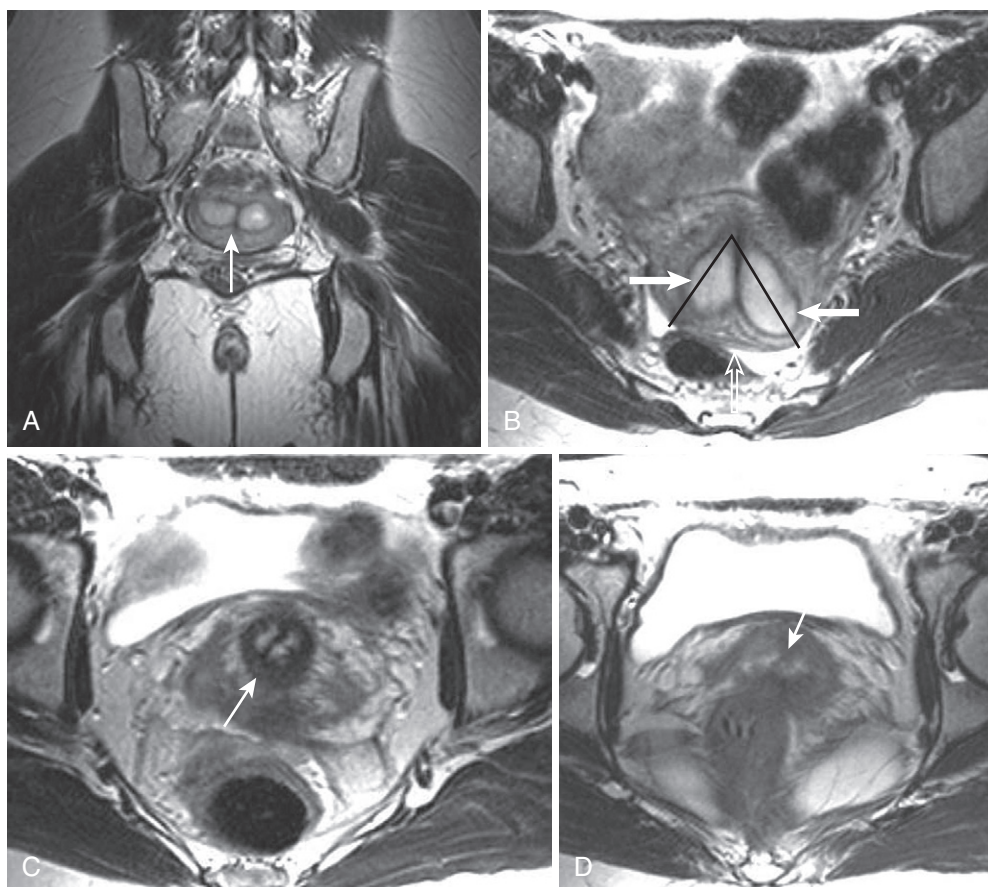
Septate uterus. A, Coronal T2-weighted image shows a hypointense fibrous septum (*arrow*) dividing the endometrial hemicavities. Axial T2-weighted images show the fibrous septum extending from the uterine fundus (B) through the cervix (C) and into the upper vagina (D) and confirming features consistent with septate uterus—convex outer fundal contour (*open arrow* in B), closely apposed uterine horns (*thick arrows* in B), and relatively low intercornual angle (*black lines* in B).
